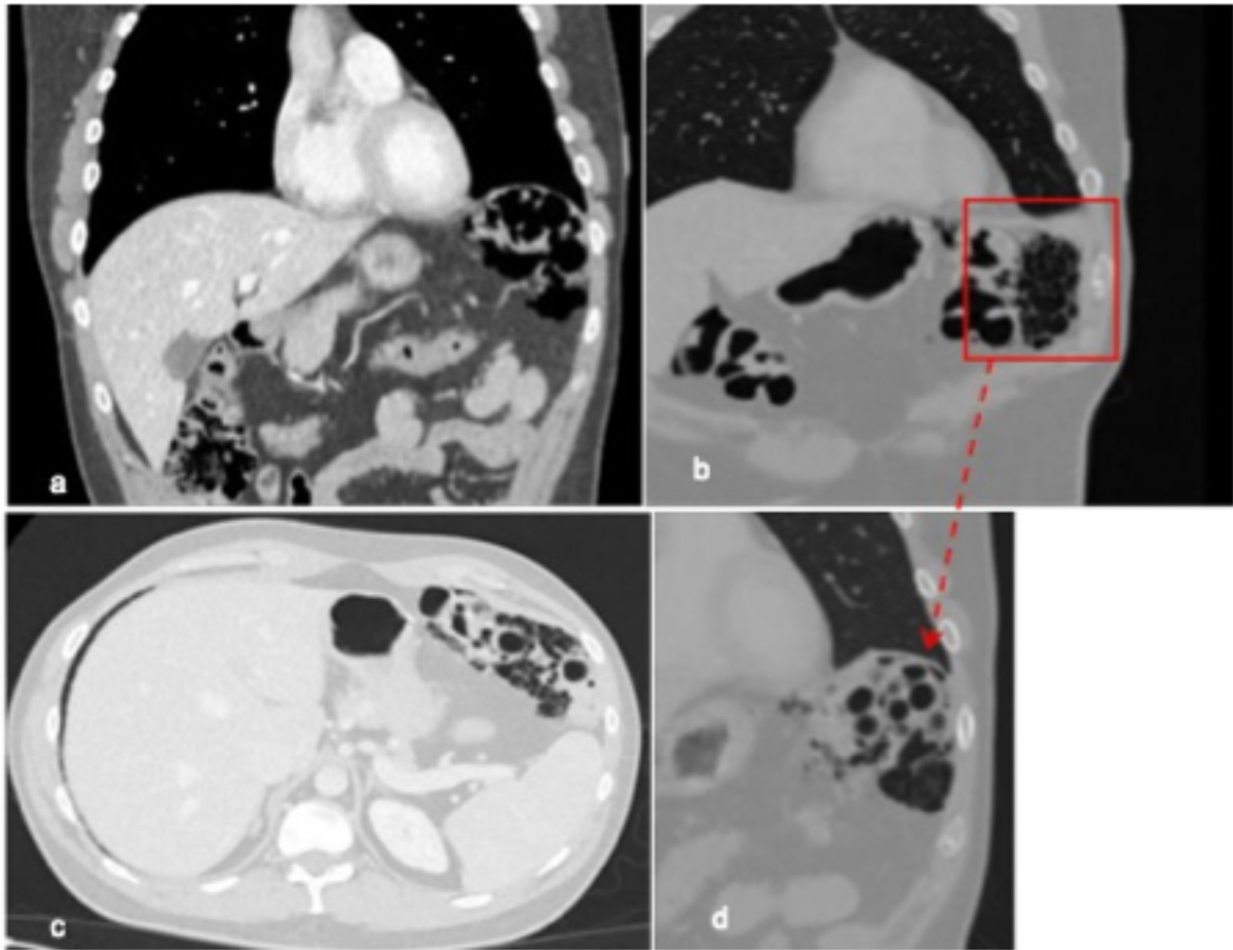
Abdominal CT images show an organized cluster of cystoid, air-filled formations within the wall of the colic intestinal loop at the junction between the transverse colon and its splenic flexure, extending longitudinally for at least 10 cm.
